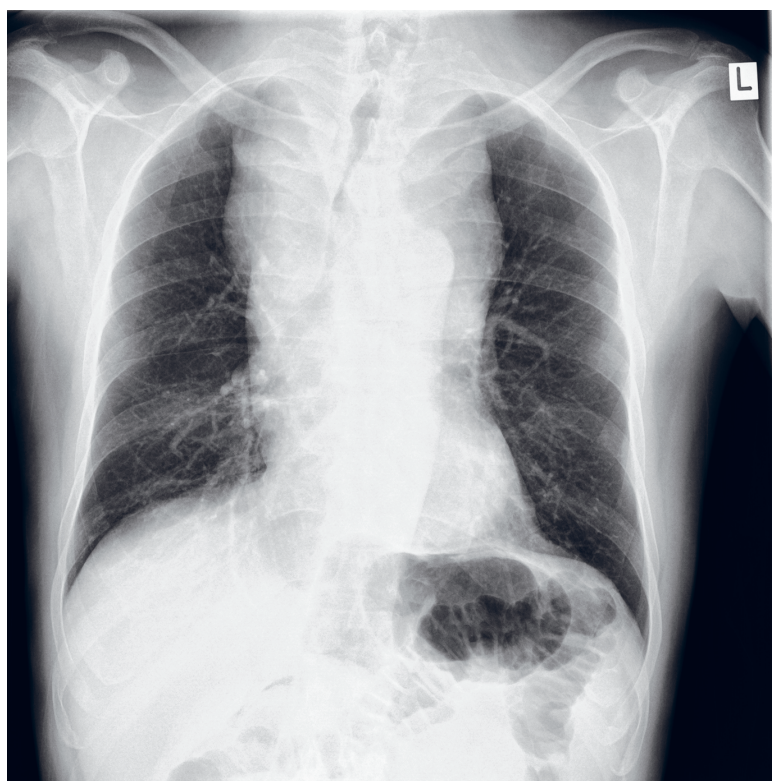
Chest radiograph. On the summation image of the thoracic organs, the shadow of the upper mediastinum is expanded. The impression of a tracheal stenosis is about 40 mm subcarinal on a 19 mm segment.
